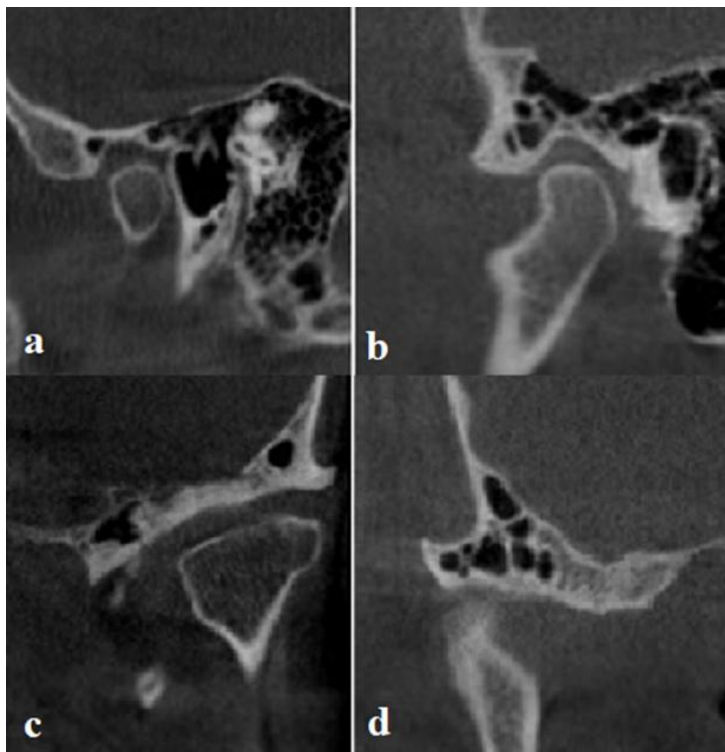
In CBCT sagittal sections; unilocular (a) / multilocular (b) PAT image and in CBCT coronal sections; unilocular (c) / multilocular (d) PAT image.
